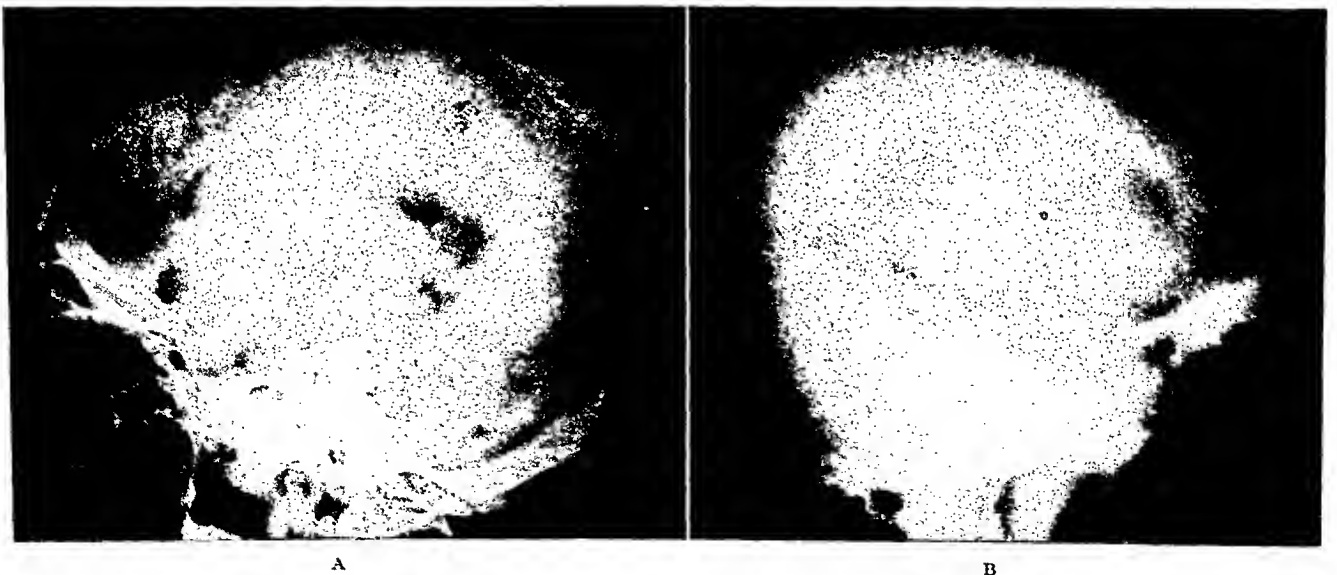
Case 77. A and B, pneumencephalographic evidence of a mass arising from region of chiasm, projecting into cisterna interpeduncularis and elevating anterior portion of third ventricle is not well demonstrated in the photographs. Advantage of a laminagram is clearly indicated. On the plain films, there is poor visualization of the sella turcica. Laminagram distinctly reveals enlargement of the sella and erosion of the anterior wall and floor.
